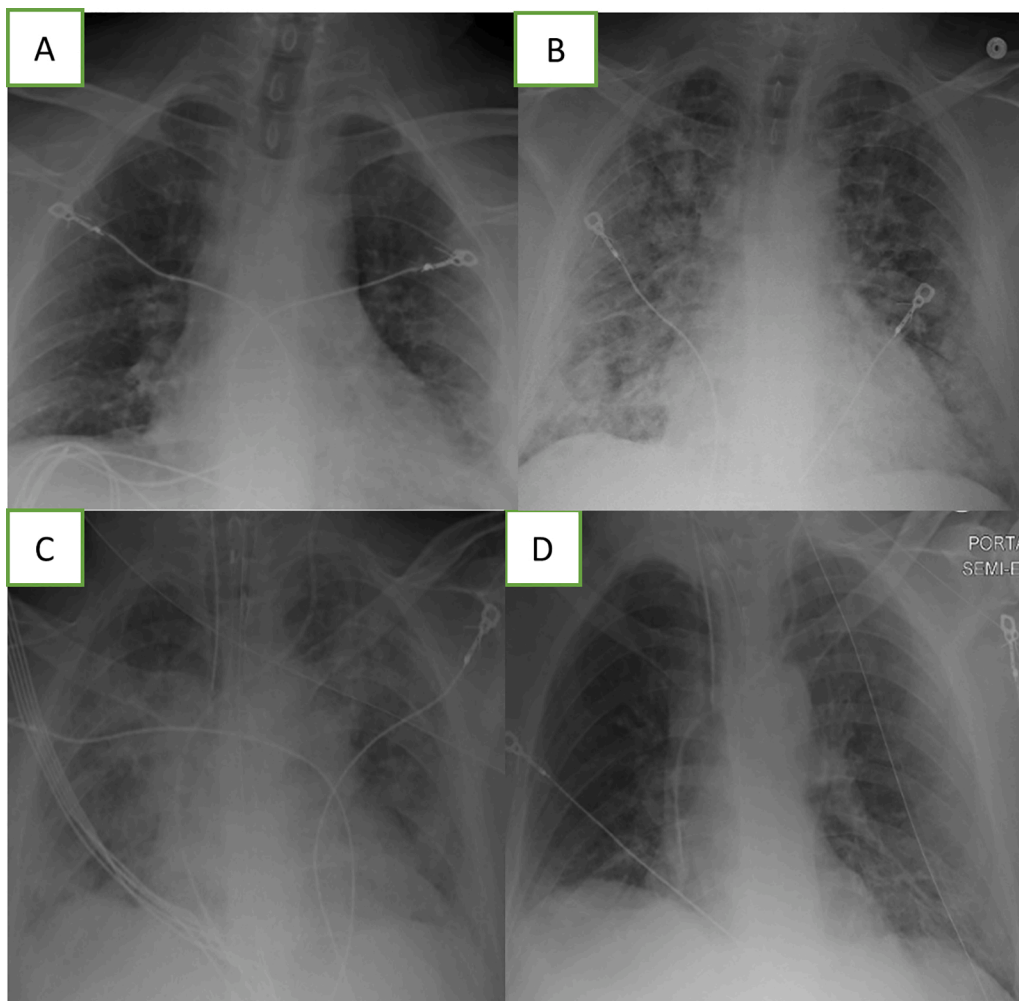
Chest x-rays before and after CCP treatment.
